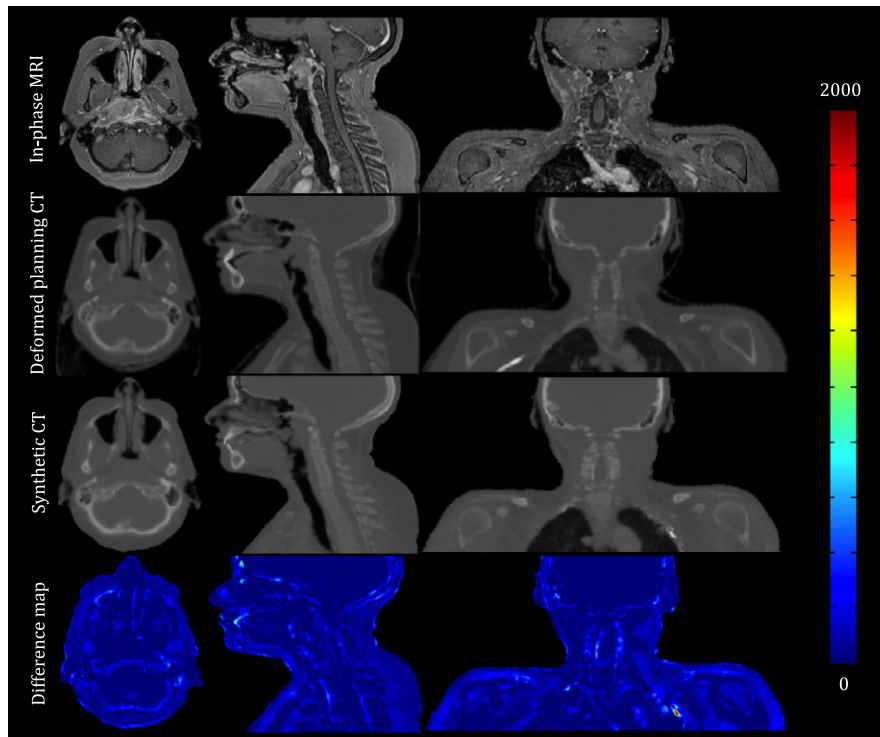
An axial, coronal, and sagittal snapshot of the In-phase MRI, deformed planning CT and synthetic CT generated using our proposed approach for patient #10. The color-coded images are the absolute difference maps between the synthetic CT and deformed planning CT. Most differences are seen in the vicinity of the air-bone and air-soft tissue interfaces. [Color figure can be viewed at wileyonlinelibrary.com]
